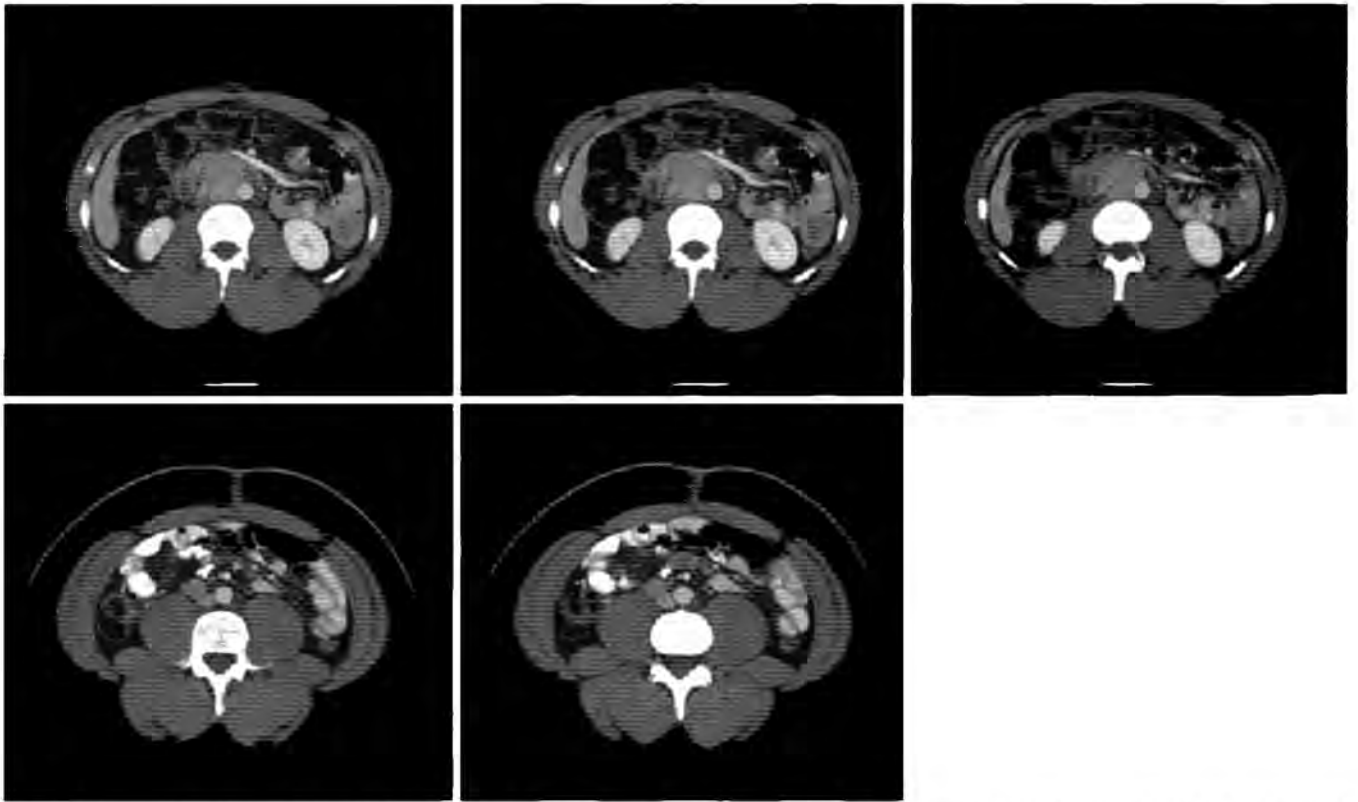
Contrast enhanced CT scan of the abdomen demonstrating two soft tissue densities aortocaval region, corresponding to the increased radiotracer uptake seen on MIBG scan.
